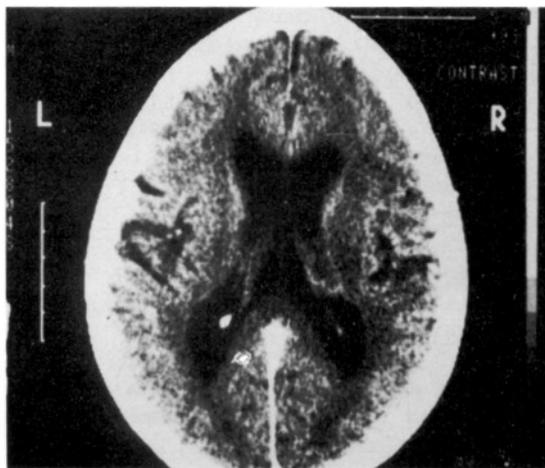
A) CT of patients 19 showing left temporal atrophy.
